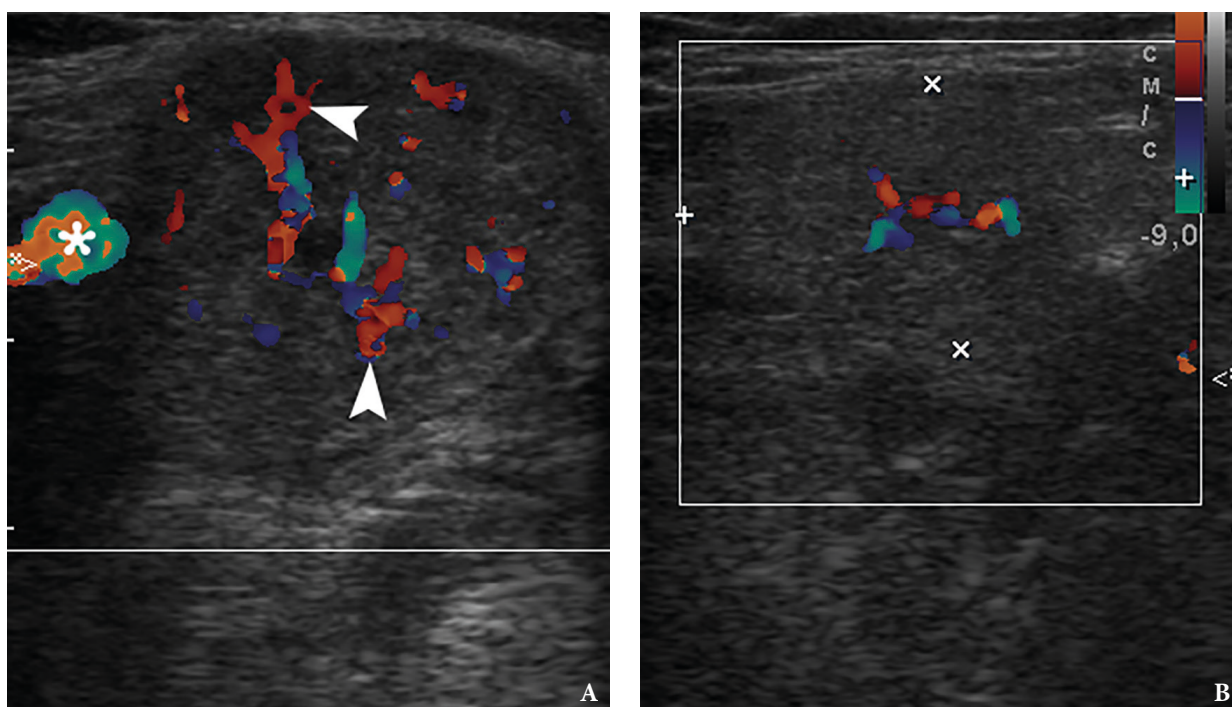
Longitudinal color Doppler ultrasound: Right inflamed submandibular gland (A) and left healthy submandibular gland (B). Comparing with a nonsymptomatic gland (B) (is indicated by '+' and 'x' calipers), the obstructed gland (A) is enlarged in two times. A striking increase of intraparenchymal vascularity (*arrowheads*) of the right gland is noted. Facial vessel is indicated by *asterisk* at image A.
